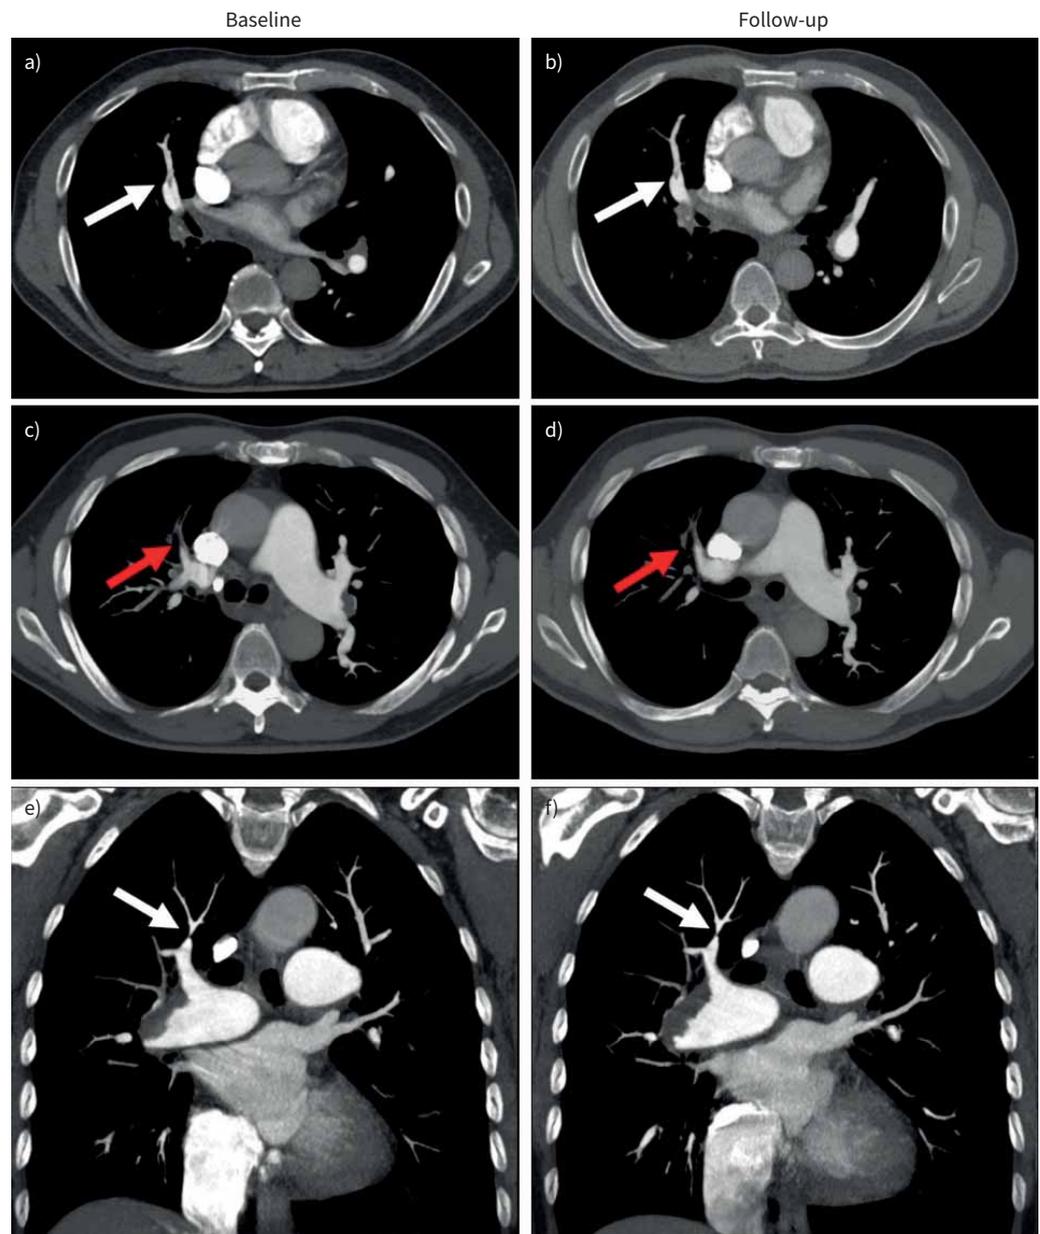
Webs and tapered pulmonary arteries did not change morphology after anticoagulant treatment. Computed tomography pulmonary angiography of a chronic thromboembolic pulmonary hypertension patient showing a) a web in the right middle lobe medial segmental pulmonary artery at baseline (white arrow) that was b) unchanged after anticoagulant treatment at follow-up; c) a tapered pulmonary artery detected in the right anterior segmental pulmonary artery at baseline (red arrow) that was d) unchanged after anticoagulant treatment at follow-up; and e) a web detected in the right posterior segmental pulmonary artery at baseline (white arrow) that was f) unchanged after anticoagulant treatment at follow-up.
